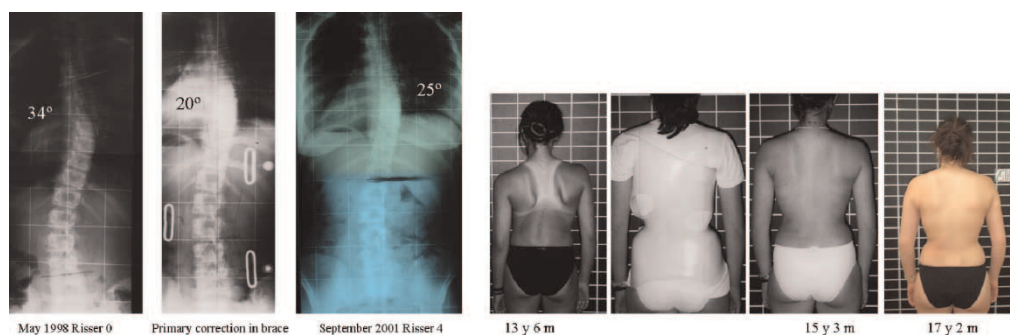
Case 2: Girl, 13 years 6 months. Scoliosis was first noticed 2 months before. Initial thoracic curvature of 34° Cobb and 10° Perdriolle was combined with a lumbar minor curve of 21° Cobb and 5° Perdriolle, with a Risser sign of 0. The girl had a pre-menarchial status. She started to wear the Rigo-System Chêneau brace (RSC-brace), a pattern specific modification of the original Chêneau brace, and had her first intensive rehabilitation programme immediately. The x-ray with the brace was taken afterwards. Correction with the first brace was 23° Cobb, 5° Perdriolle (thoracic) and 16° Cobb, 10° Perdriolle (lumbar). A second brace was built 1 year later correcting the thoracic curvature to 20° Cobb, 5° Perdriolle and the lumbar curvature to 18° Cobb, 5° Perdriolle. When she was 15 years 3 months, she judged her own cosmetic appearance as impressively good. She left the brace at 16 years 6 months. A new x-ray was taken at 16 years 9 months. The last picture shows her cosmetic aspect months later. She still does her exercises regularly.
